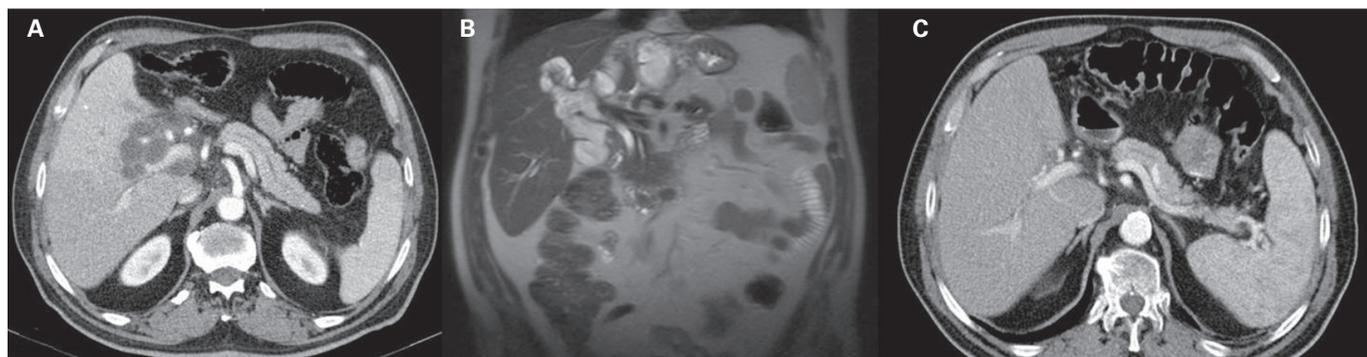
Abdominal computed tomography (CT) and abdominal magnetic resonance (MR) and magnetic resonance cholangiopancreatography (MRCP). A. Abdominal CT. Dilatation of the left intrahepatic biliary ducts with a bile duct of 10 mm in the liver hilum and an area of low attenuation with internal septums of approximately 5 x 8 x 10 cm, suggestive of a multiloculated liver abscess. B. MR and MRCP. Intrahepatic biliary duct dilatation persists and peribiliary cysts have increased in size and compress the biliary ducts. C. Abdominal CT. Peribiliary cysts have disappeared and are also associated with abscesses.
